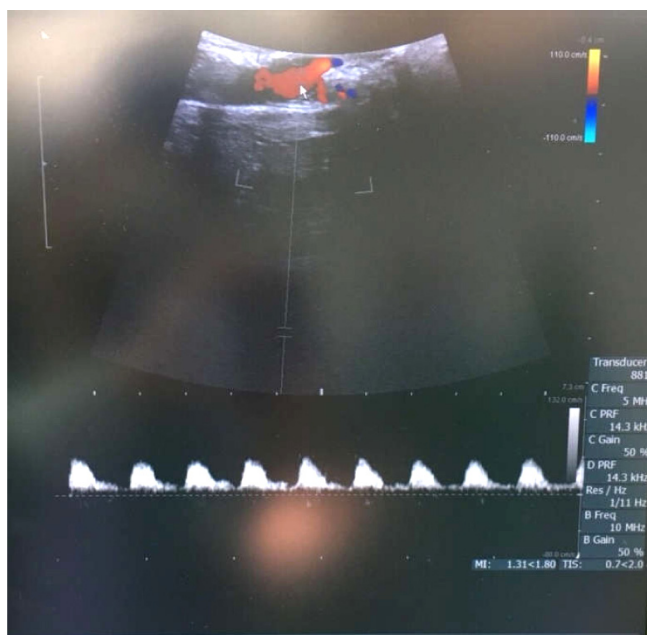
Intra-operative duplex ultrasound showed a celiac artery peak-systolic velocity of 120 cm/sec, verifying adequate decompression.
